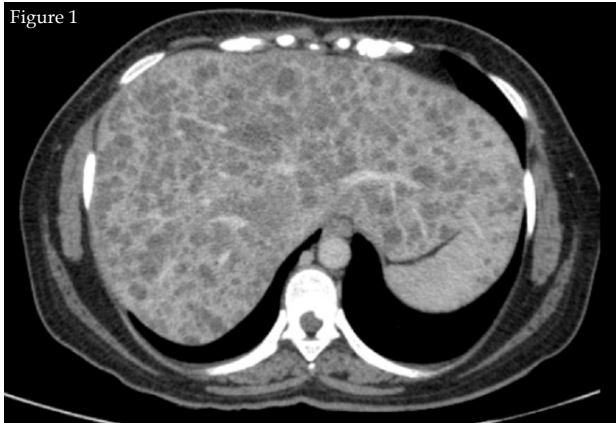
and 2 Showing multiple cystic lesions in liver on CT-scan. These lesions do not show enhancement on post-contrast images. No calcification and fat component seen within it. No central dot sign is seen.
